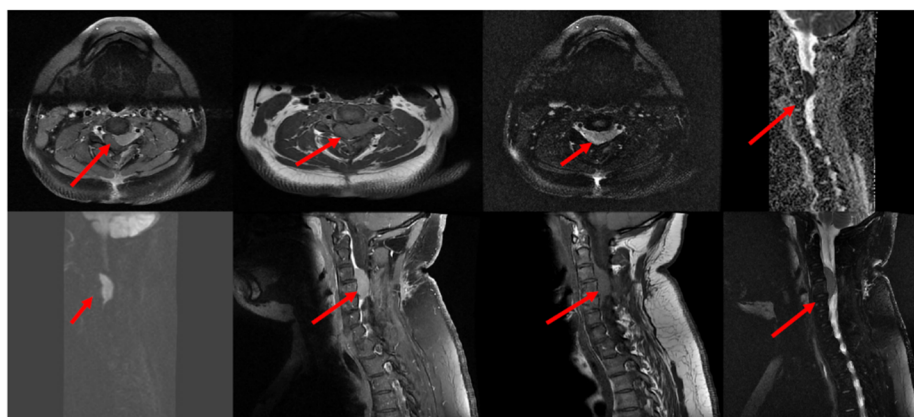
MRI of the cervical spine showed that there is an intraspinal epidural mass (arrows) measuring 1.2 x 1.8 x 3.2 mm (AP, TV and CC diameters) in the ventrolateral aspect at the level of C3-C4 extending to the left neural foramen, impinging the adjacent nerve root and compressing the spinal cord with cervical myelopathy. The mass demonstrates avid homogeneous enhancement in postcontrast study and DWI restriction. Abbreviation: Magnetic resonance imaging (MRI), anteroposterior (AP), transverse (TV), and craniocaudal (CC) planes.
